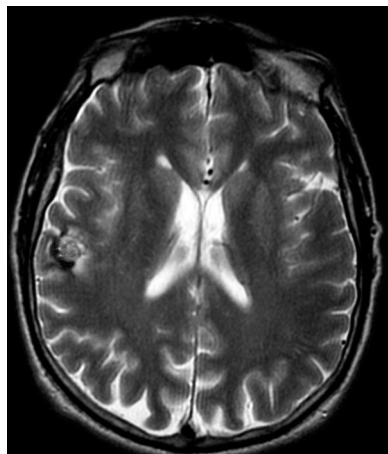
Patient P., proband's father. Cerebral cavernous malformation of the right frontal lobe. Magnetic resonance image before operation, T2.
